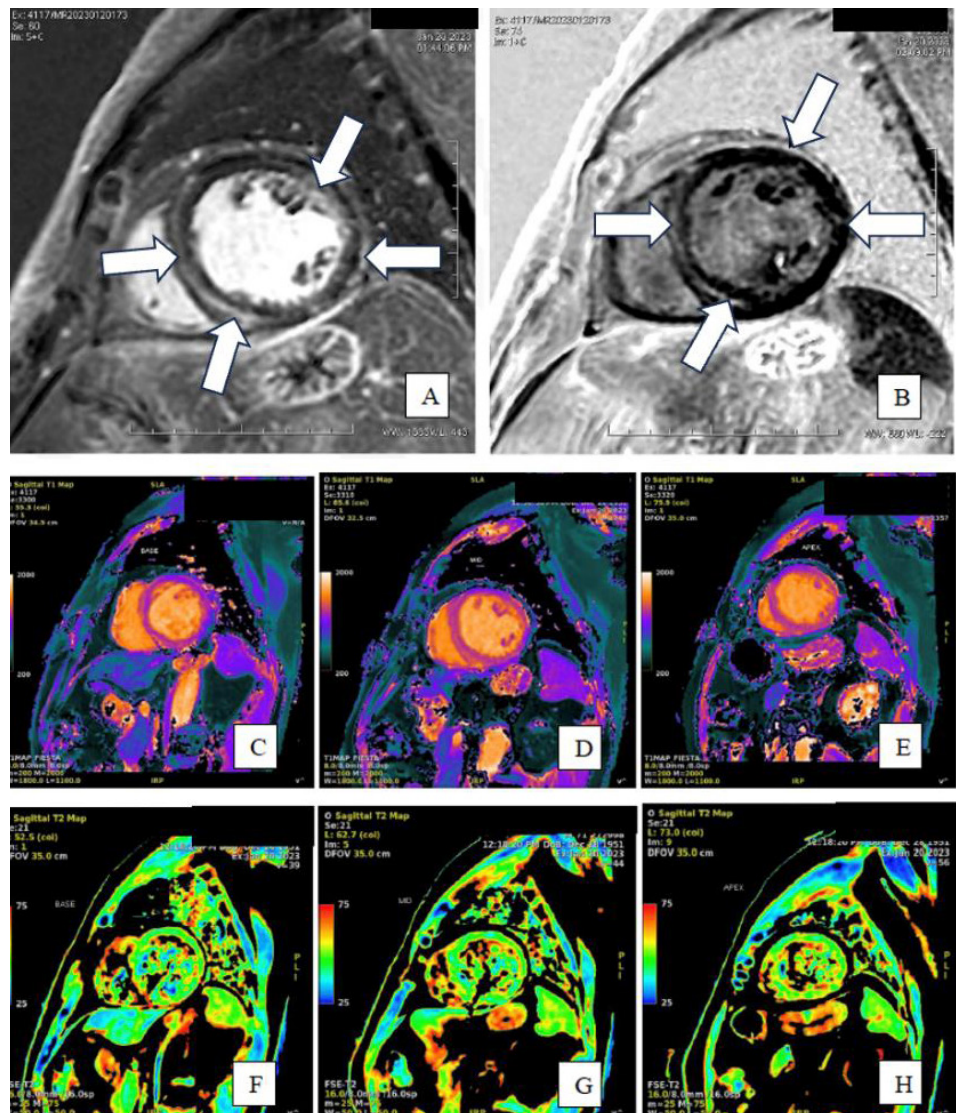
MRI examination. A, B. LGE showing non-ischemic pattern of hyperenhancement involving mid myocardium of inferoseptal, anteroseptal, anterior, and lateral walls. C-H. T1-T2 mapping showing increased T1 and T2 value in inferoseptal, anteroseptal, and lateral walls of the left ventricle. Left: base. Middle: Mid-section. Right: apex. (white arrow).
